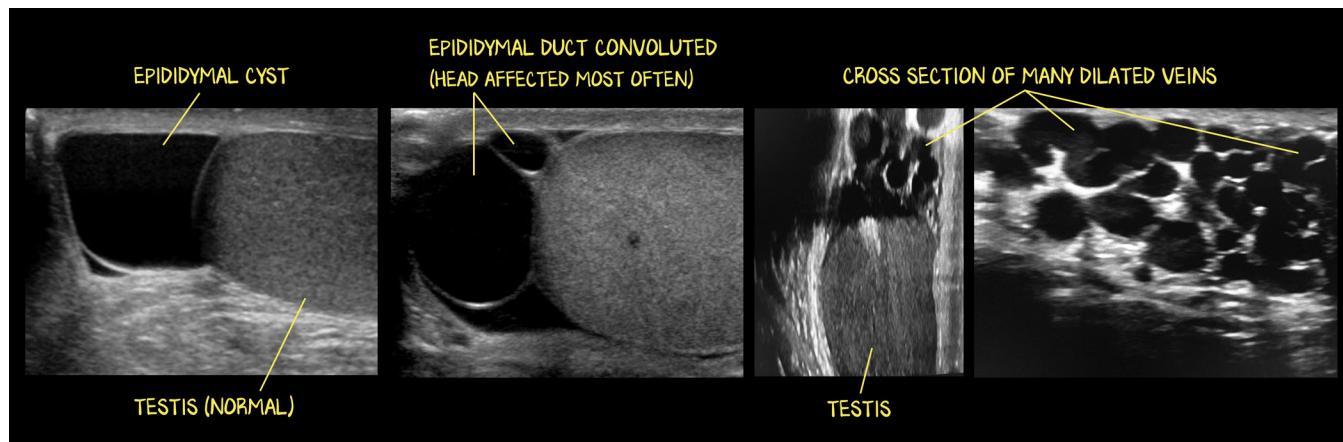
Ultrasonographic Spermatocele and Varicocele
